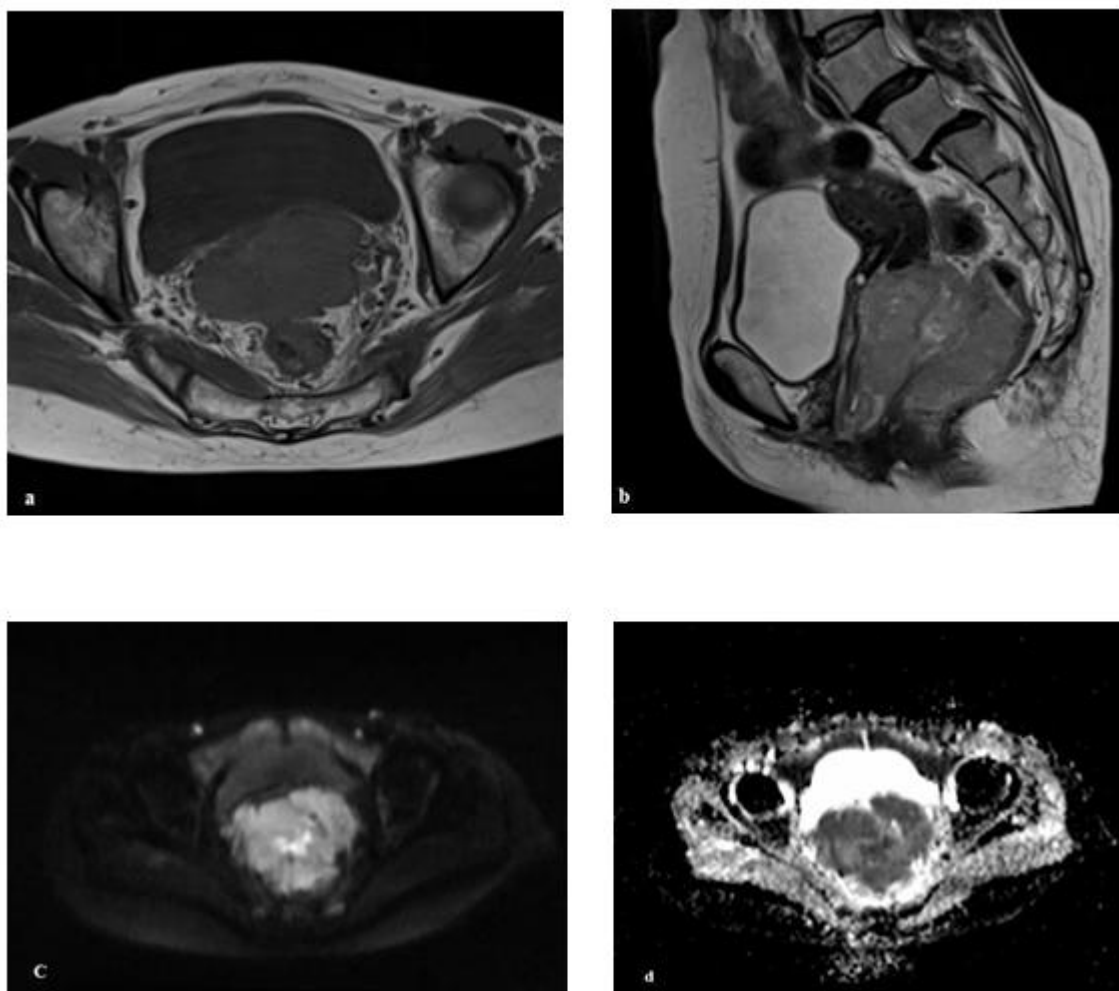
(a)T1W axial sequence shows that there is a distinct isointense lesion noted comprising the posterior wall of the cervix, with extension into the posterior and right lateral wall of cervix.(b) T2W sagittal sequence shows that there is a distinct hyperintense lesion noted comprising the posterior wall of the cervix, with extension into the posterior and right lateral wall of cervix, invading the rectum. (c)DWI axial sequence shows areas of hyperintensity in the mass
